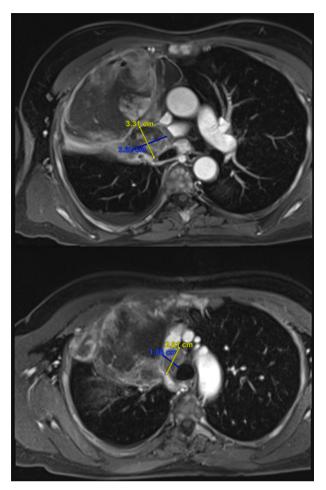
MR Images of Metastatic Disease. Axial MR images of large necrotic mass in right upper lobe and paratracheal/hilar lymphadenopathy with associated narrowing of the superior vena cava.
